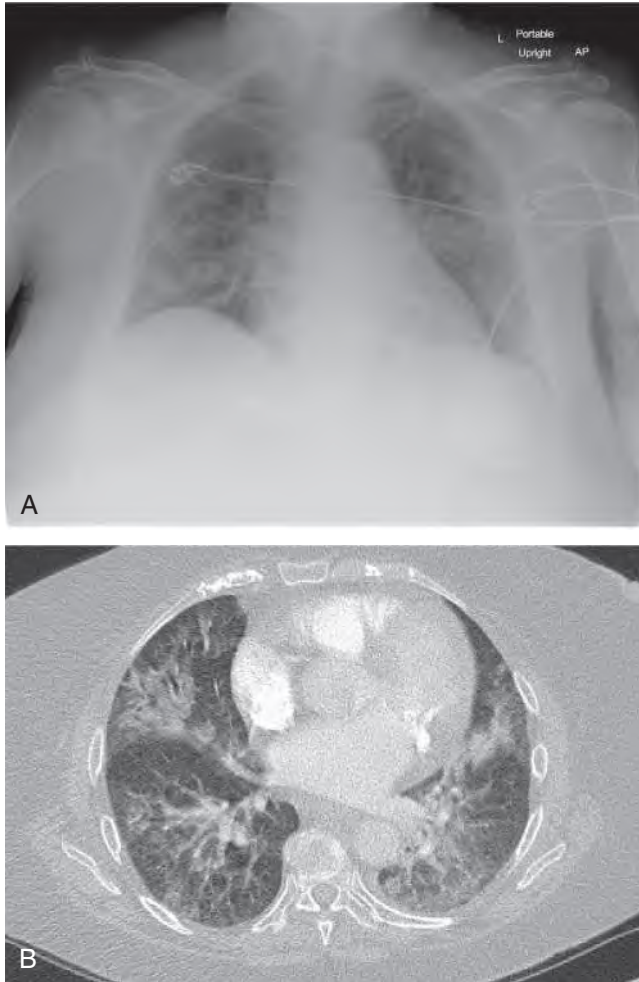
(A) Chest radiograph showing patchy opacities in the right lower and left mid and lower lung zones in a patient with human metapneumovirus pneumonia. (B) Computed tomographic scan, sagittal view, showing extensive patchy ground-glass consolidations in all lobes of the lungs of same patient with human metapneumovirus, obtained 3 days after chest radiograph.
